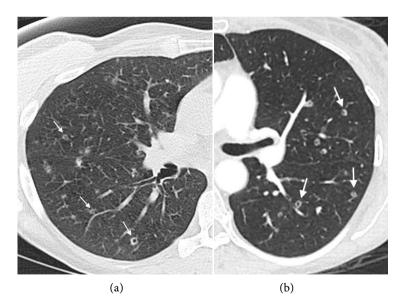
Cheerio type cysts in LCH and metastasis. (a) This 54-year-old woman had a chronic cough. The CT image shows several small thick-walled cysts proven to be due to LCH. (b) This 54-year-old woman had a history of colon cancer. The CT image shows several thick-walled cysts due to metastasis.
